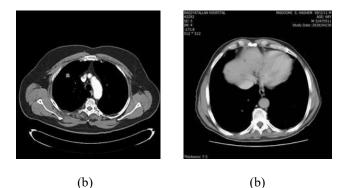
Lung CT Scan images (a)Cancerous image and (b) non-Cancerous image
